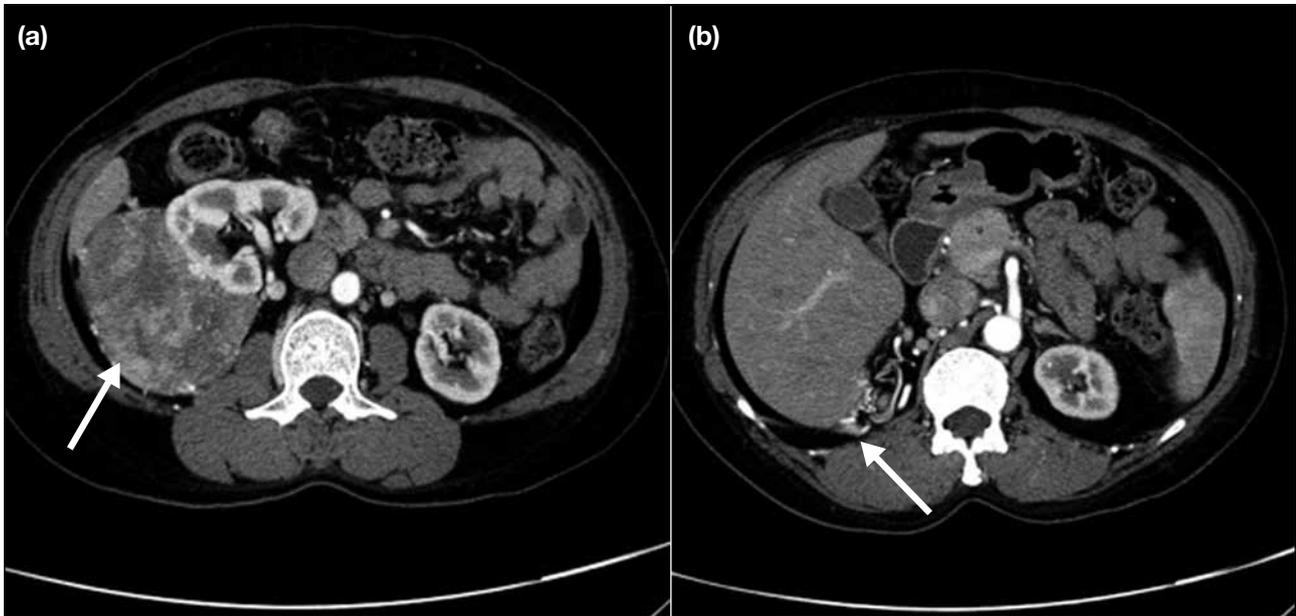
Computed tomography of the abdomen with contrast. (a) A large heterogeneous, enhancing retroperitoneal mass (arrow) is found closely abutting the posterior aspect and displacing the right kidney. (b) The lesion (arrow) was supplied by multiple tortuous branches from the aorta. Neither kidney shows any focal solid mass. There are no enlarged intra-abdominal lymph nodes.
